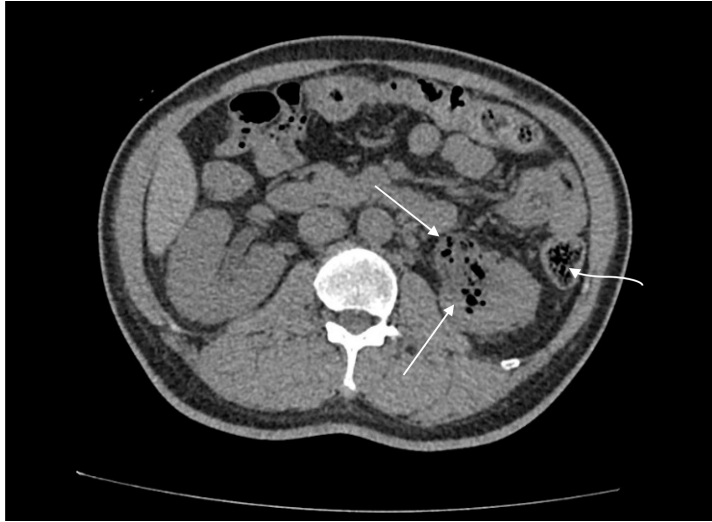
Axial image of plain computed tomography at the renal level. The dilated left pelvicalyceal system with multiple fecaloid materials within the left renal pelvis (arrow) until the proximal ureter was observed. Note that it appears similar to faecal materials within the descending colon (curve arrow).
